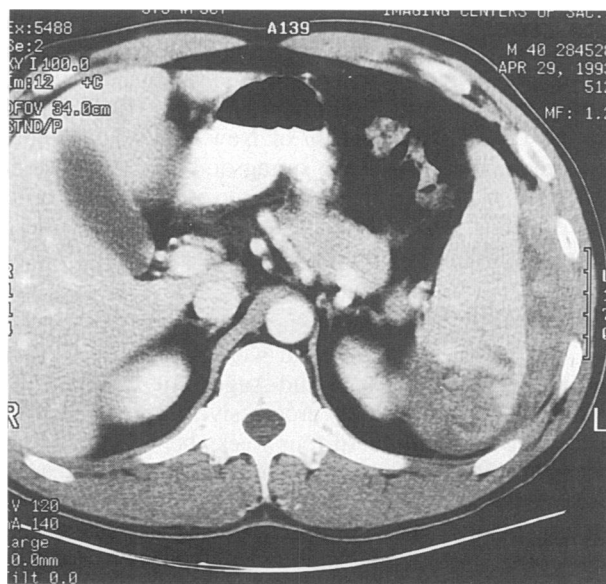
A computed tomographic scan of the abdomen with contrast shows a subcapsular splenic hematoma and a tear in the splenic parenchyma.
